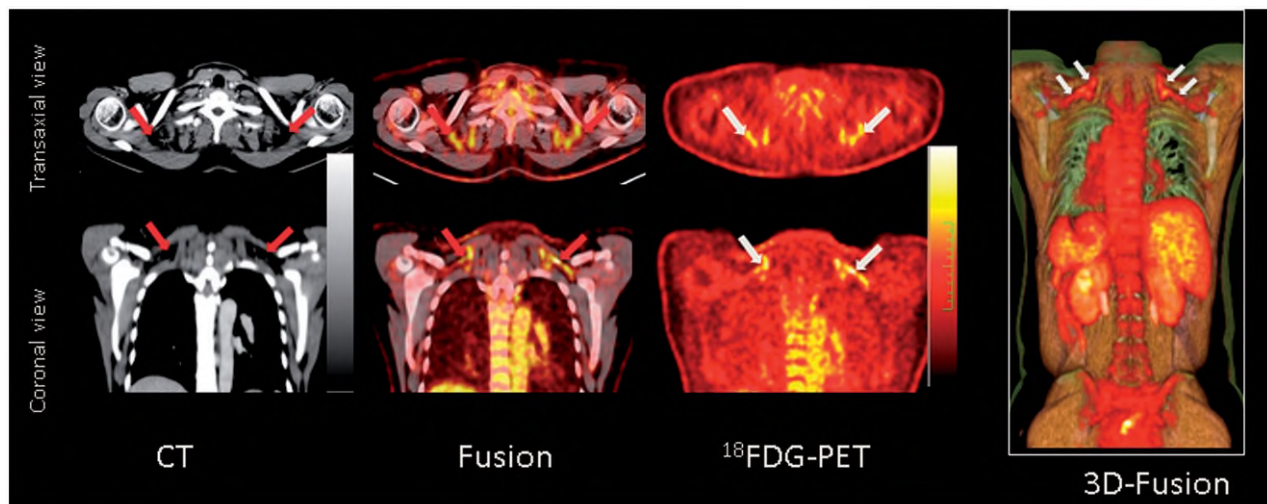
Activated brown adipose tissue in a patient with low TH levels and a history of thyroid cancer. A 43-year-old woman with a history of papillary thyroid cancer presenting during short-term profound hypothyroidism (TSH, 168 mU/L) while off all thyroid hormone treatment as part of restaging with whole-body ¹³¹I-imaging. Due to elevated thyroglobulin levels and an unremarkable ¹³¹I-scan, FDG-PET/CT was performed, revealing metabolically active brown adipose tissue in the supraclavicular regions (arrows).
